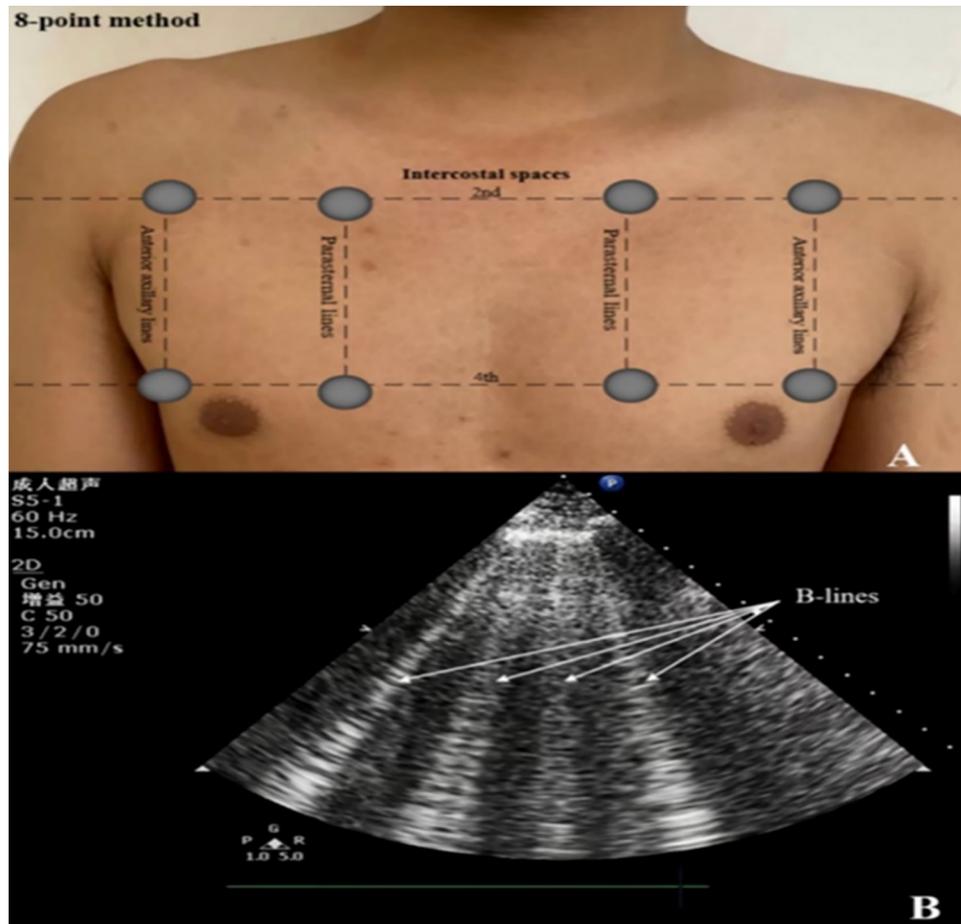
Detection of B-lines by lung ultrasound.
